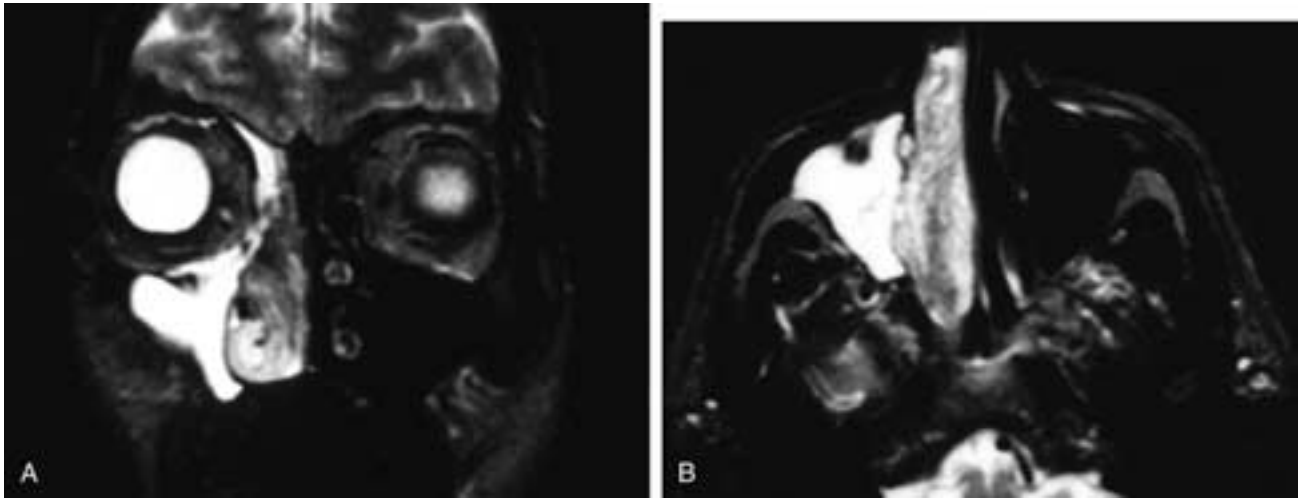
Coronal (A) and axial (B) T2-weighted MR images show a polypoid, nonhomogeneous right nasal fossa mass that has intermediate signal intensity. The right maxillary sinus, the right lateral ethmoid sinuses, and the lower nasal fossa have high signal intensity material that represents obstructed secretions. The tumor does not extend directly to the orbital margin. Such a high degree of tumor mapping was not possible on CT, where the secretions and tumor had similar attenuations. This patient had an inverted papilloma and obstructed secretions.
